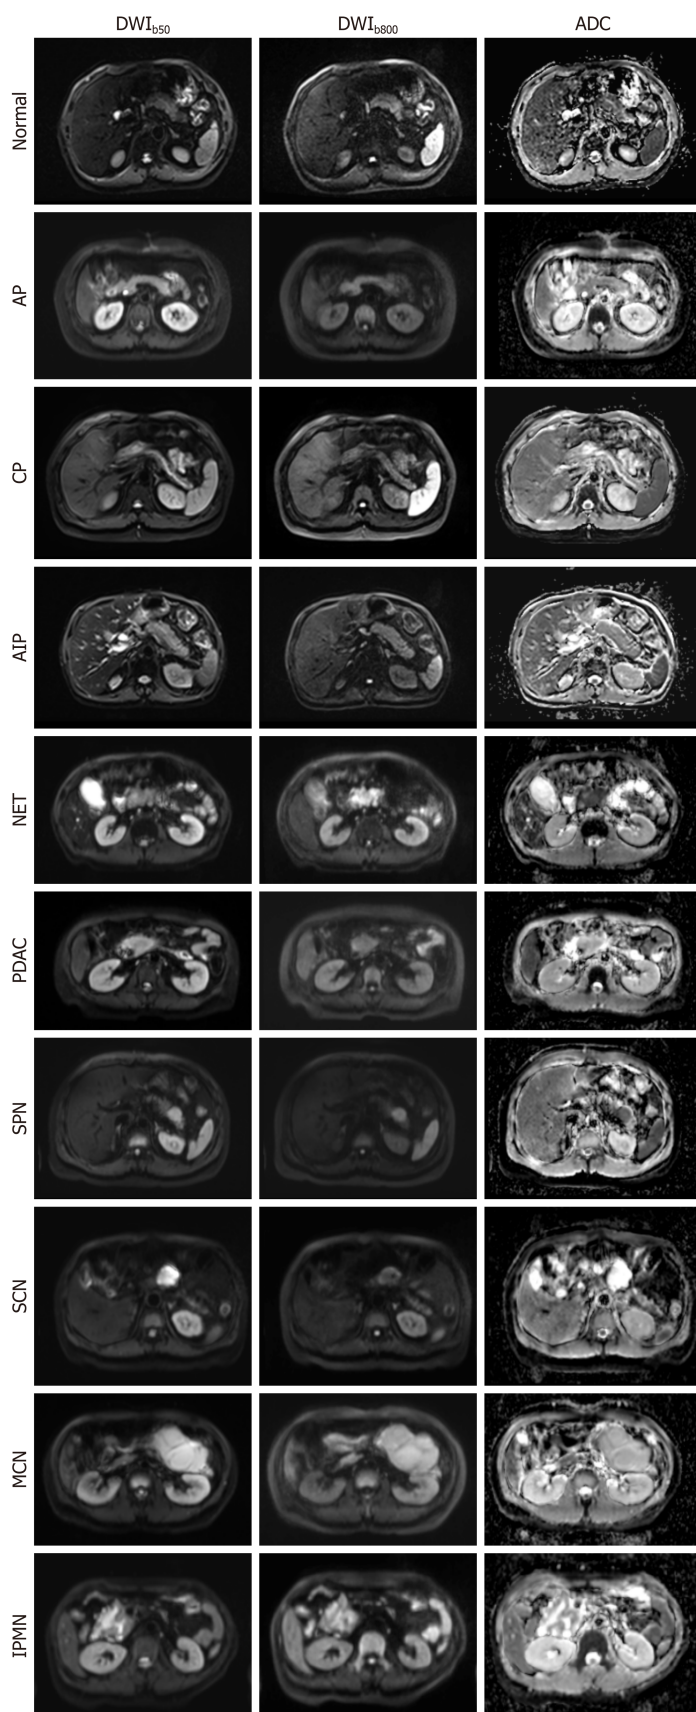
Diffusion-weighted imaging and corresponding apparent diffusion coefficient maps of the normal pancreas and nine representative pancreatic pathologies, acquired on a 3.0-T system with b-values of 50 and 800 s/mm². AP: Acute pancreatitis; CP: Chronic pancreatitis; AIP: Autoimmune pancreatitis; NET: Neuroendocrine tumor; PDAC: Pancreatic ductal adenocarcinoma; SPN: Solid-pseudopapillary neoplasm; SCN: Serous cystic neoplasm; MCN: Mucinous cystic neoplasms; IPMN: Intraductal papillary mucinous neoplasm; DWI: Diffusion-weighted magnetic resonance imaging; ADC: Apparent diffusion coefficient.
